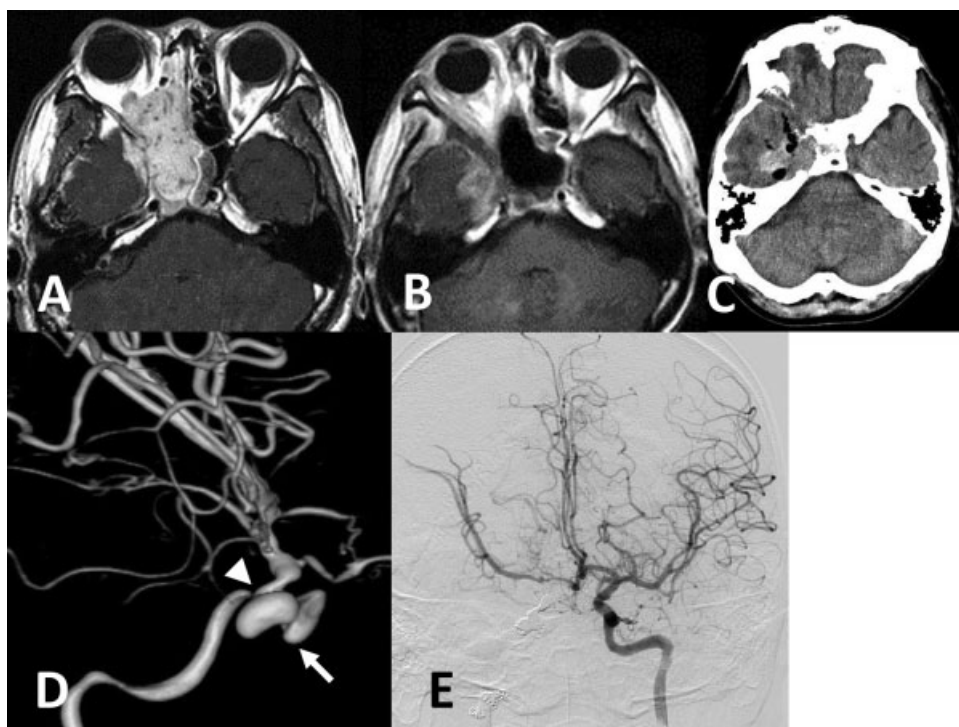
(A) Axial T1-weighted magnetic resonance image with gadolinium (MRI-Gd) before the surgery revealed the tumor in the orbit and ethmoid sinus adjacent to the right internal carotid artery (ICA). (B) Axial MRI-Gd after the third stereotactic radiotherapy demonstrated remarkable shrinkage of the tumor. (C) Computed tomography scan on emergent admission due to massive epistaxis revealed the hematoma at the middle cranial fossa and pneumocephalus. (D) Right internal carotid angiogram showed a right petrous ICA aneurysm (arrow) with slight stenosis of the adjacent ICA (arrowhead). (E) Left internal carotid angiogram after the endovascular treatment revealed the tolerable cross-flow via the anterior communicating artery.
